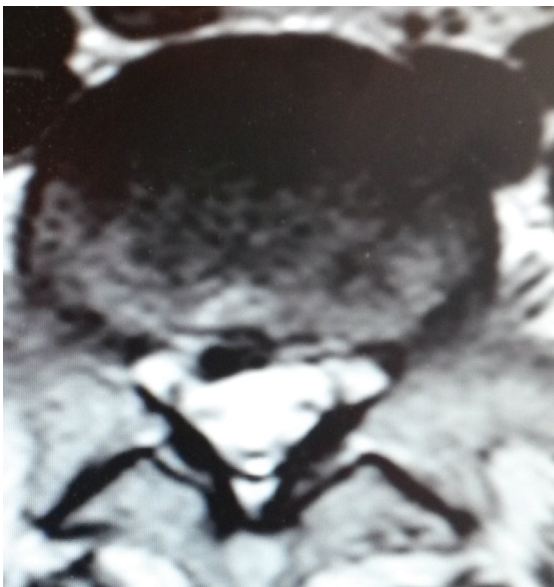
Axial T2-weighted MRI showed signs of right paracentral side disc fragment at the L5-S1 level (a 41-year old)
